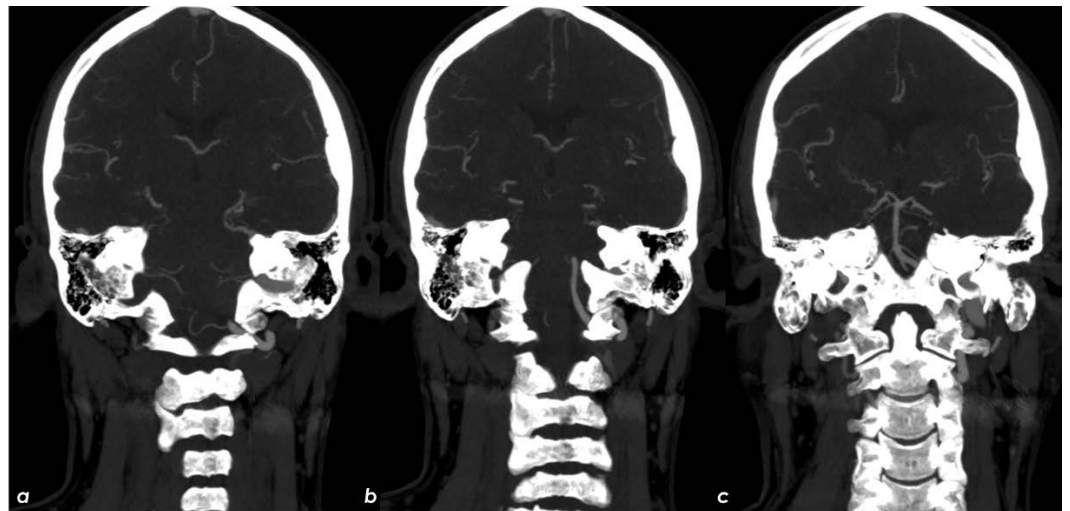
Arch-to-vertex CTA with MIP reconstructions in the coronal plane. The lack of contrast filling of the right distal V3 (a) and V4 (b) VA is evident in comparison to the left VA starting from the dural ring with retrograde filling of the pre-junctional segment (c).
